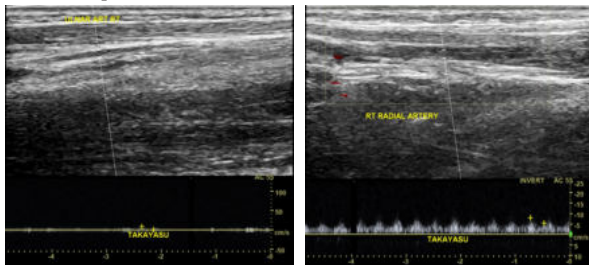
CASE 4: Ultrasound shows involvement of right radial and ulnar arteries.
